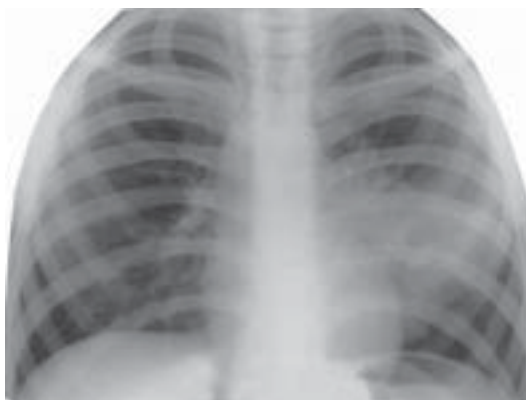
Primary tuberculosis complex (infiltration phase) of the left lung. Observation roentgenogram of the thoracic cage organs in the direct projection.
